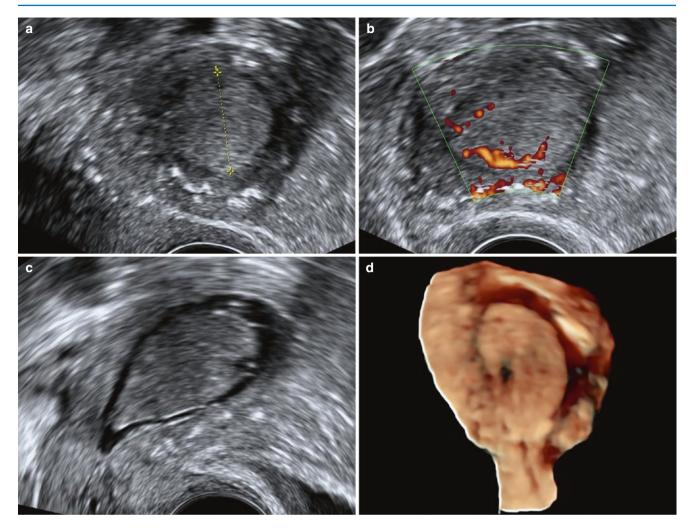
Endometrial polyp in a postmenopausal patient. (a) Regular TVS showing a thick hyperechoic endometrium of 19 mm. (b) Regular TVS showing vessels in the endometrium on Doppler. No single prominent feeder vessel was, however, noted. (c) SHG showing an unanticipated teardrop-shaped large endometrial polyp conforming to the shape of the endometrial cavity. (d) 3D rendered image showing the endometrial polyp attached to the posterolateral wall of the uterus
